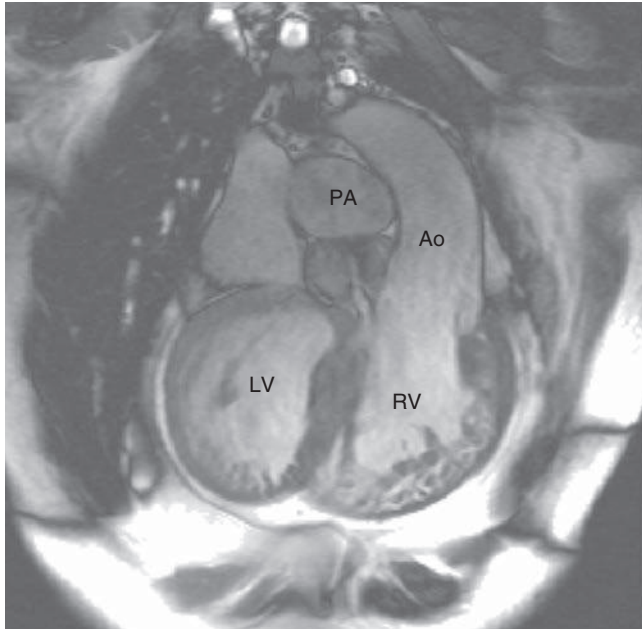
Magnetic resonance image of double-outlet right ventricle (DORV) in an adult with atrioventricular discordance in whom satisfactory imaging for three-dimensional relationships could not be fully achieved with other modalities. Note the left-sided systemic right ventricle (RV; coarse trabeculations) giving rise to the aorta (Ao) and more than 50% of the pulmonary artery (PA), and thus the DORV relationship. Also note subvalvular and valvular pulmonary stenosis. LV, Left ventricle.
